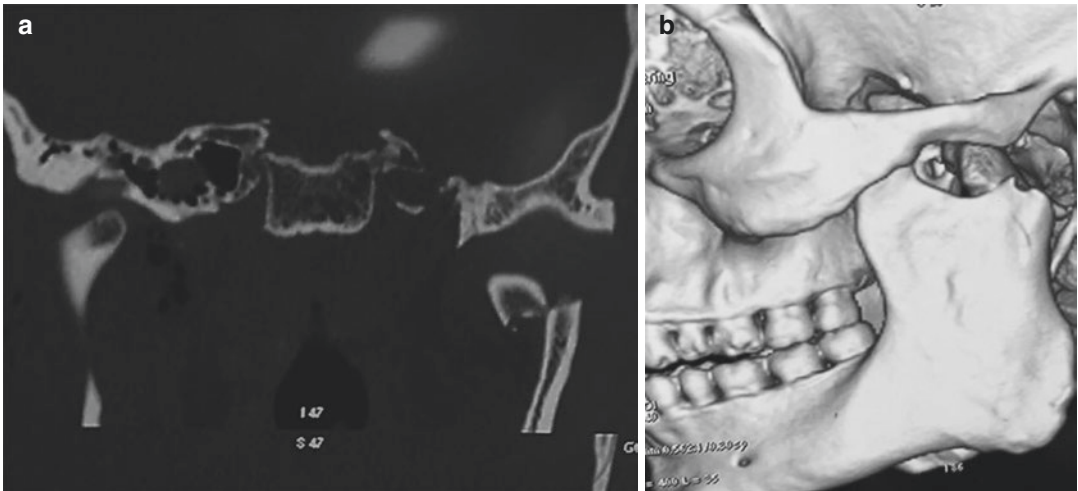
Computed tomographic (CT) scan (a) coronal section, (b) 3D reconstructed image demonstrating an antero-medially displaced fractured mandibular condyle (pulled along the tangential force of the lateral pterygoid muscle)
